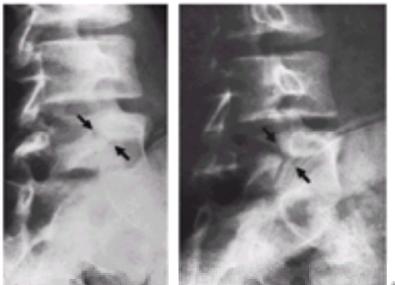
A: The radiograph of a 5-year-old girl with normal appearance of the lumbosacral junction. B: The same person at age 15. Spondylolysis and grade I spondylolisthesis have developed in the interim with symptoms referable to the low back. Spondylolysis in children occurs after walking age, but rarely before 5 years, and more commonly at 7 or 8 years. Onset of symptoms coincides closely with the adolescent growth spurt.
